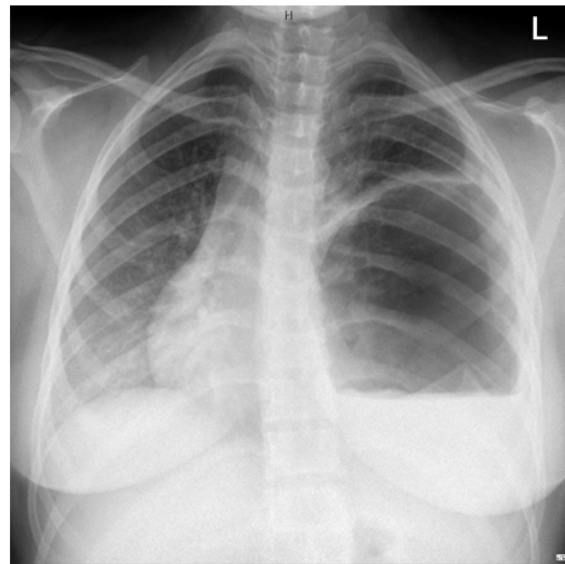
A chest X-ray showed a very large (14x13 cm) pulmonary cystic lesion with fluid level seen, occupying the mid and lower aspect of the left lung. The lesion that resulted in marked pressure on the heart and a marked mediastinal shift to the right side, Subtle opacity is seen in relation to the right lower zone
